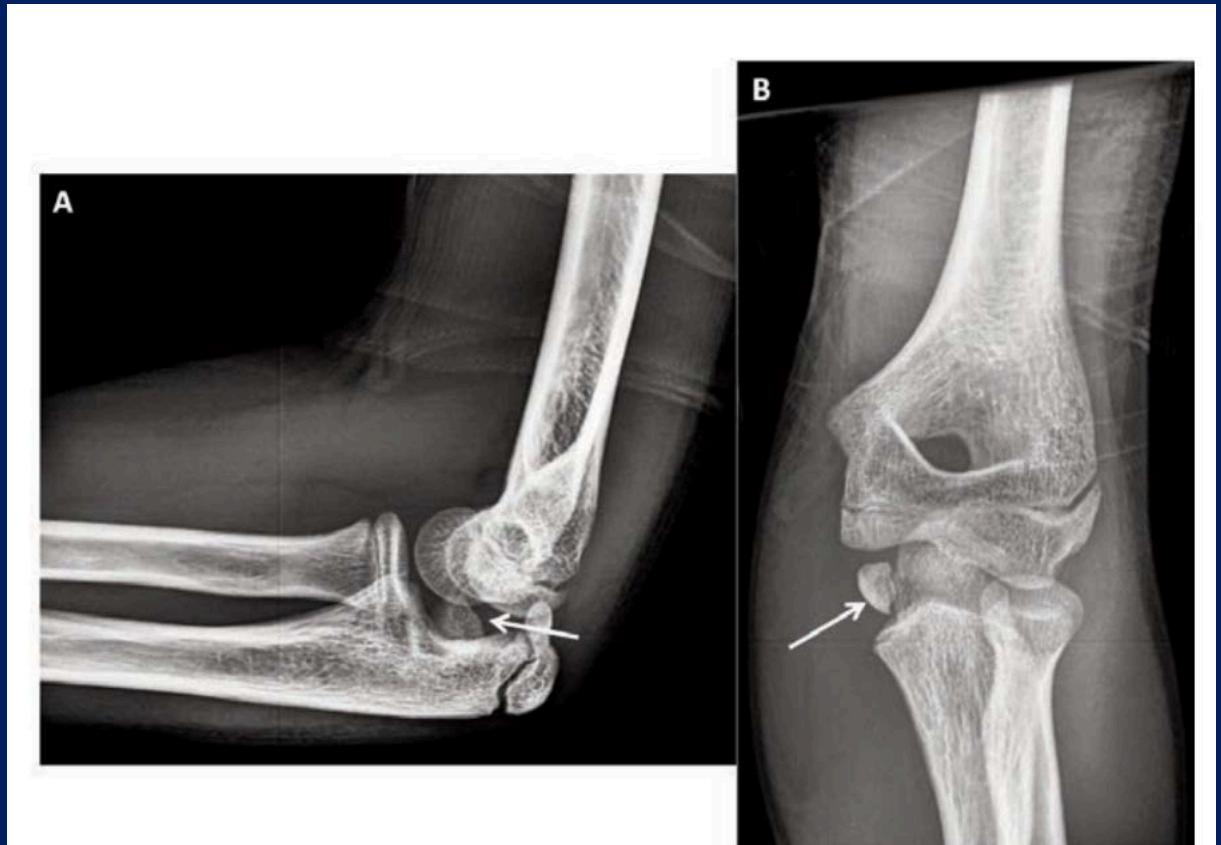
A) Lateral radiograph showing an incarcerated medial epicondyle fracture (white arrow). B) Anteroposterior radiograph depicting the same (white arrow).
